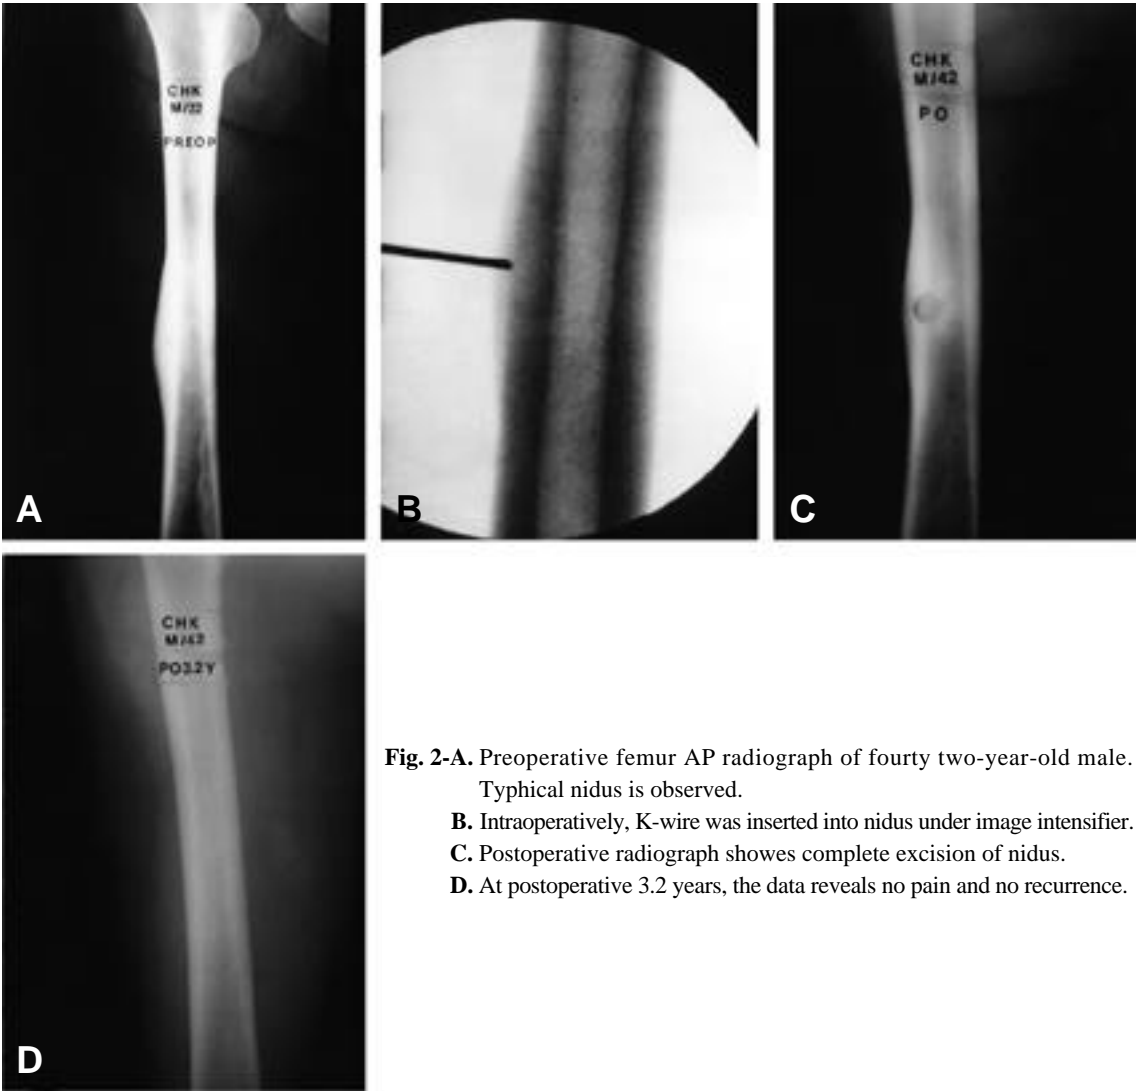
Preoperative femur AP radiograph of forty two-year-old male. Typical nidus is observed.
